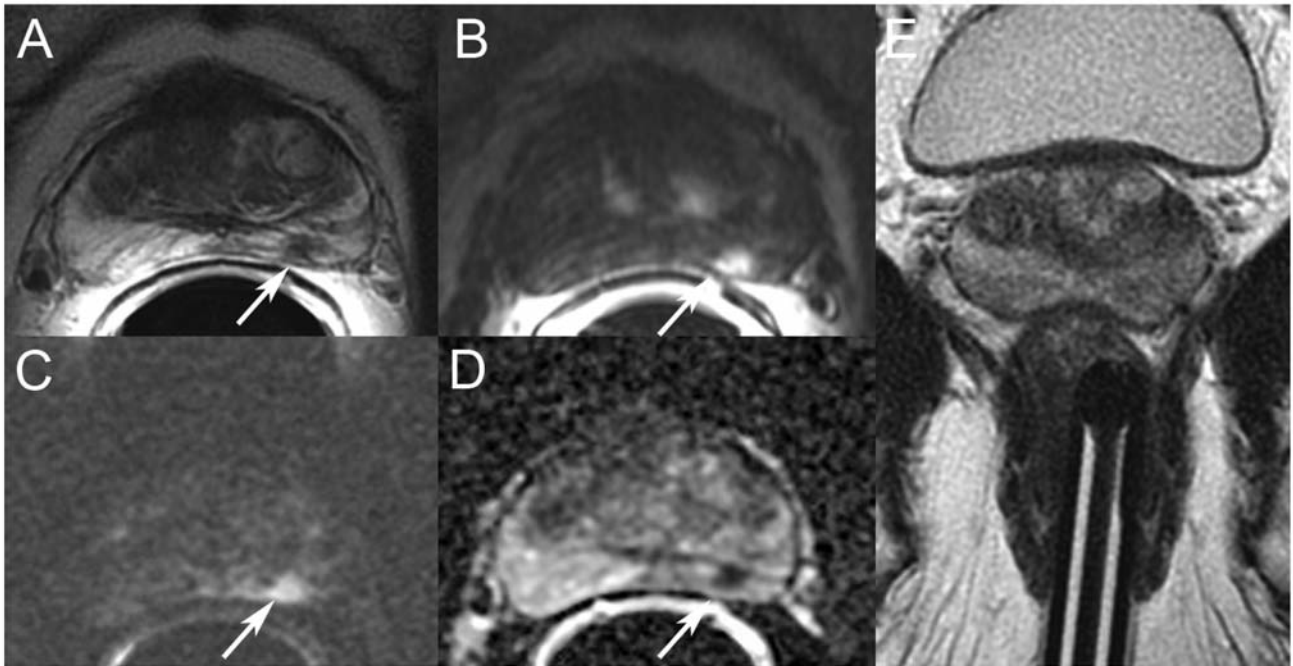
Results of prebiopsy mp-MR imaging of a 72-year-old male with PSA level of 4.9 ng/ml. MR imaging detected a hypointense area in the left peripheral zone on T2-weighted imaging (A, arrow). Signal intensity was increased on both dynamic contrast-enhanced and diffusion weighted imaging with b-value 1,000 s/mm² (B and C, arrow), while a low signal intensity was present on ADC map (D, arrow). Patient underwent in-bore MR-guided transrectal prostate biopsy (E) and a Gleason Score 3+4 occurred in 2/2 targeted cores.
